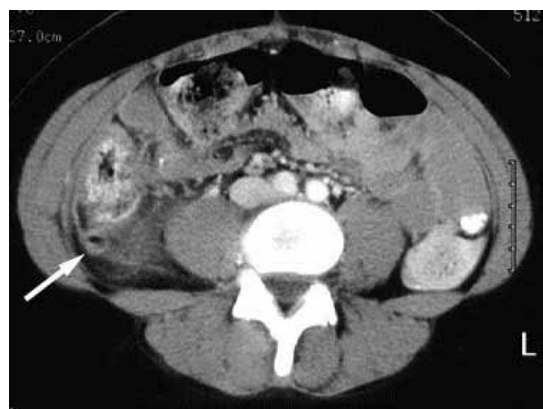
appendicitis by CT scan.
